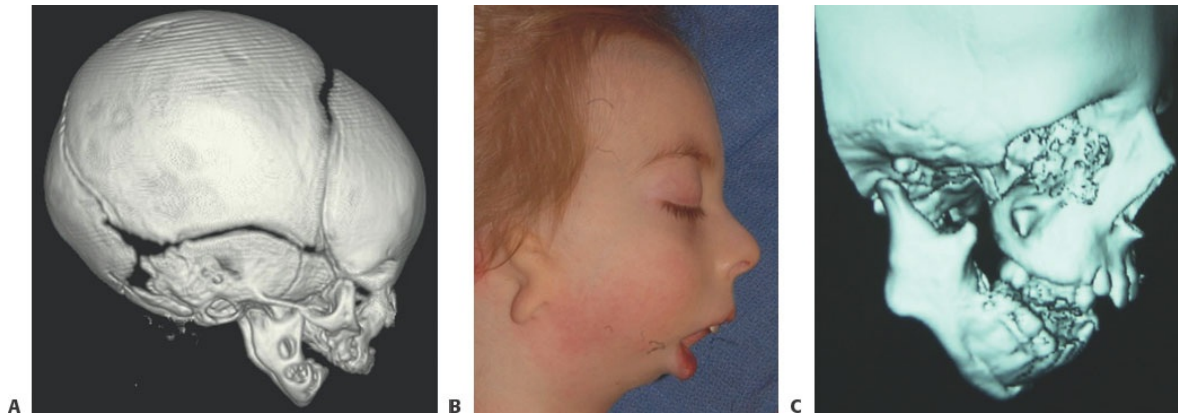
• A. CT scan showing the bilateral micrognathia in Pierre Robin sequence (PRS). B. Patient with hemifacial microsomia (HFM) demonstrating severe micrognathia. C. Patient with Treacher Collins syndrome (TCS) exhibiting severe micrognathia (both mandibular body and ramus), and an anterior open bite.
